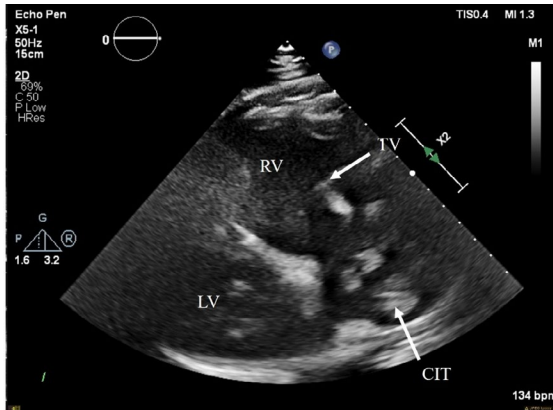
Echocardiogram, right ventricle tilt view demonstrates clot in transit (CIT), TV (tricuspid valve), RV (right ventricle), LV (left ventricle).
